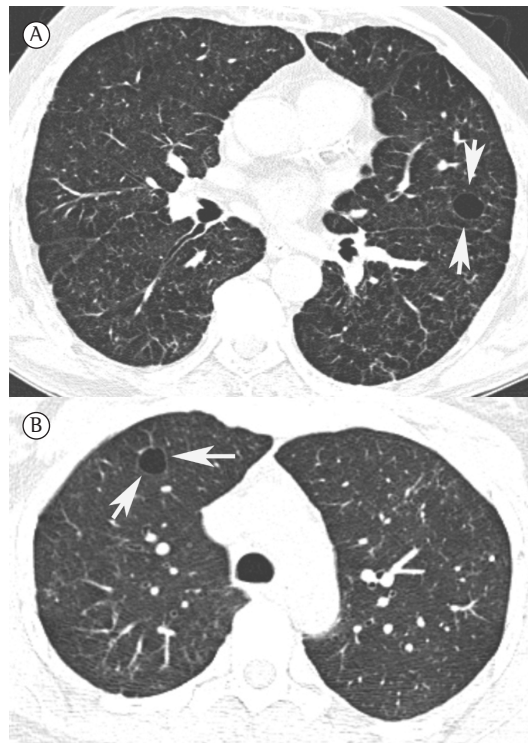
HRCT scans. In A, HRCT scan slice at the level of the aortic arch showing a thin-walled cyst in the right lung of a 41-year-old female patient (arrows). Also note faint reticular and nodular opacities in the lung, which are probably residual in nature. In B, HRCT scan slice at the level of the lower lobes showing a thin-walled cyst in the left lung of a 68-year-old male patient (arrows). Note the presence of faint reticular opacities predominantly in the posterior regions.
